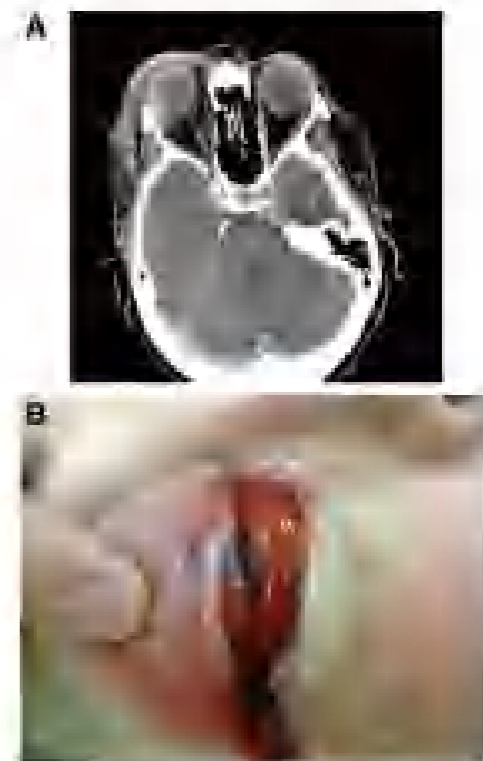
(A) Axial computed tomography (CT) scan demonstrating proptosis of the orbit and mass in the superolateral orbit. (B) Intraoperative photograph of the orbit showing the orbital mass during surgery.
